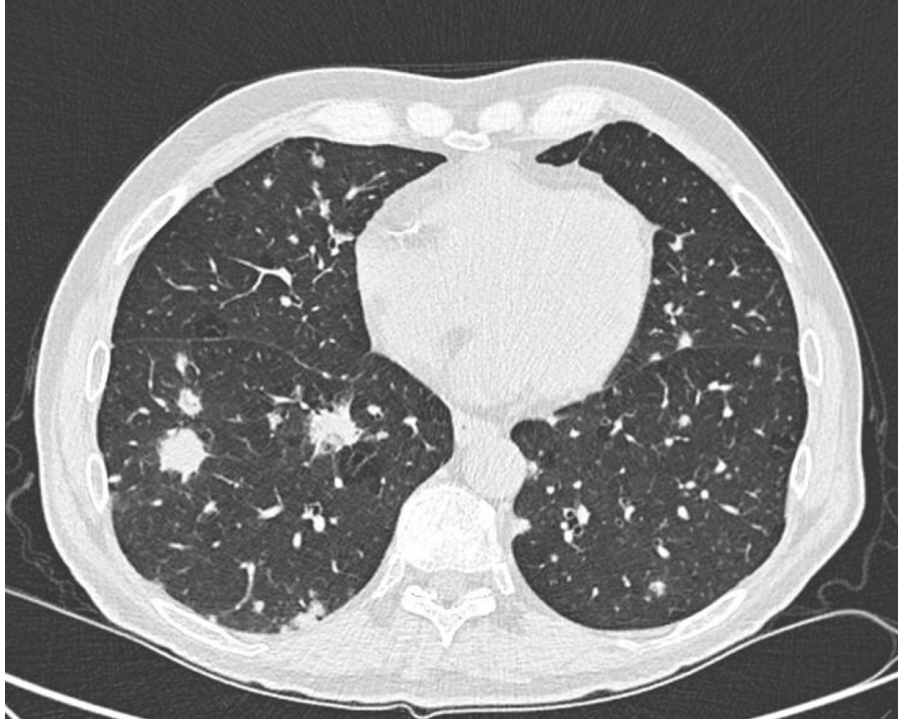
CT halo sign in invasive pulmonary aspergillosis. Ground-glass opacity (hemorrhage) surrounds a dense nodule (fungal infarct), producing the characteristic halo appearance. This sign is most useful in the first 5–7 days and may disappear as disease evolves. Note that it can also occur with mucormycosis and other angioinvasive infections.
